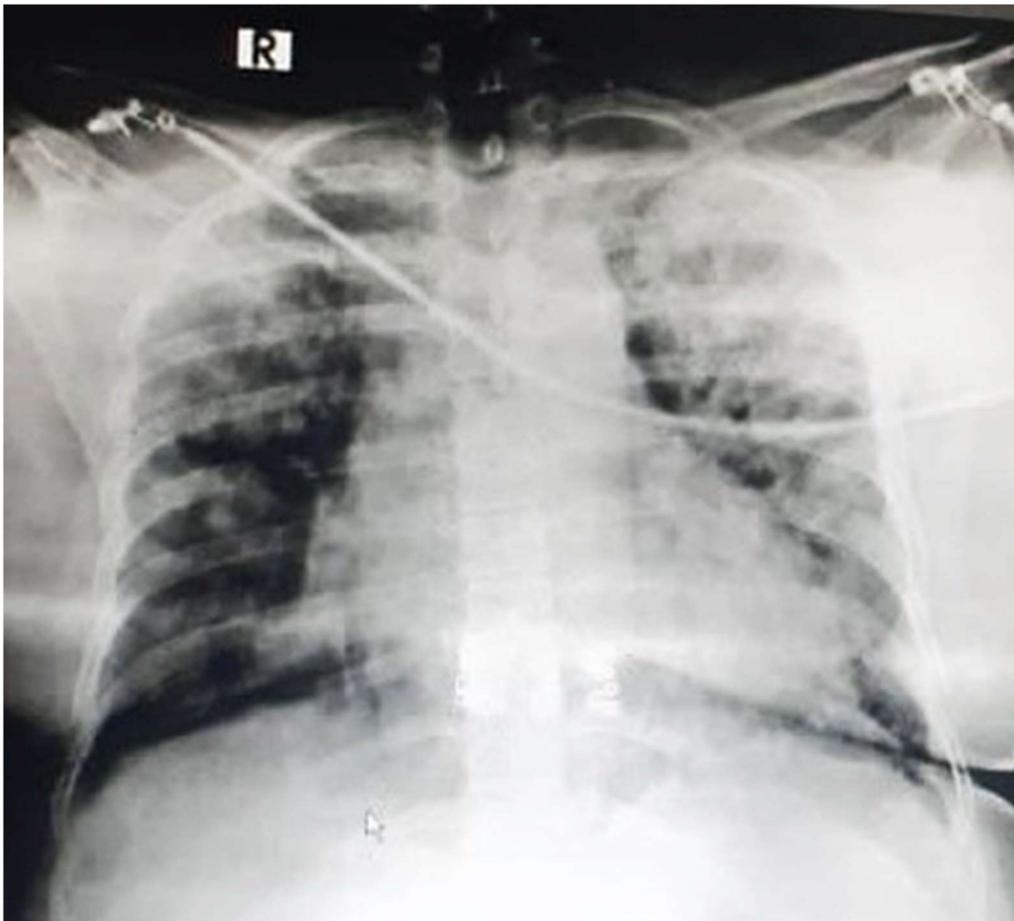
Baseline anterior-posterior view (AP) chest radiographs of case 4.
